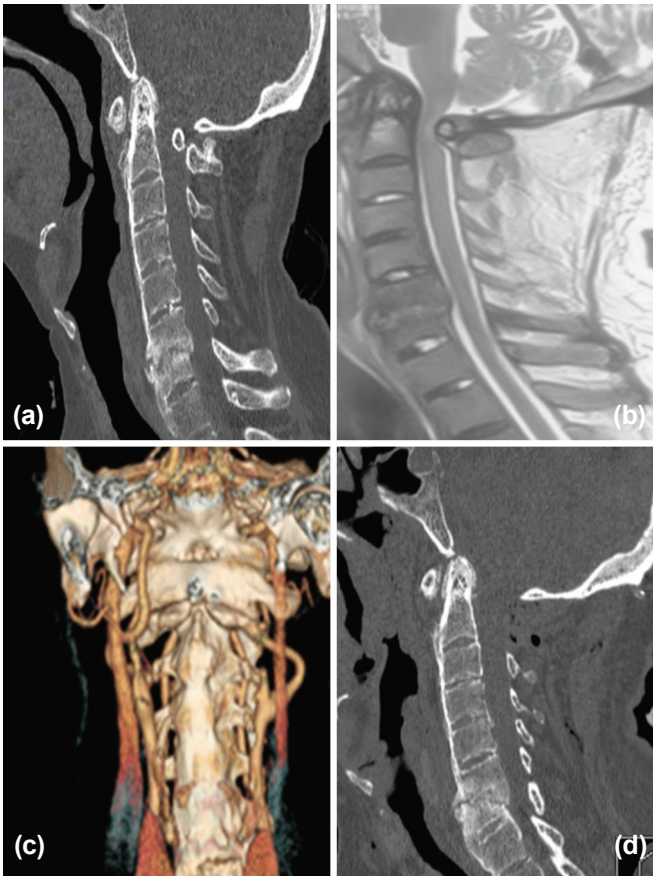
In ankylosing spondylitis patient (a) Preoperative CT mid-sagittal cervical spine showing straightening and ankylosis of cervical vertebrae with canal stenosis at atlas. (b) MRI showing cord compression at atlas due to posterior C1 arch. (c) Surface shaded display coronal CT cervical spine showing fusion of posterior spinous processes. (d) Postoperative CT cervical spine showing absence of C1 posterior arch and C2 posterior elements.
